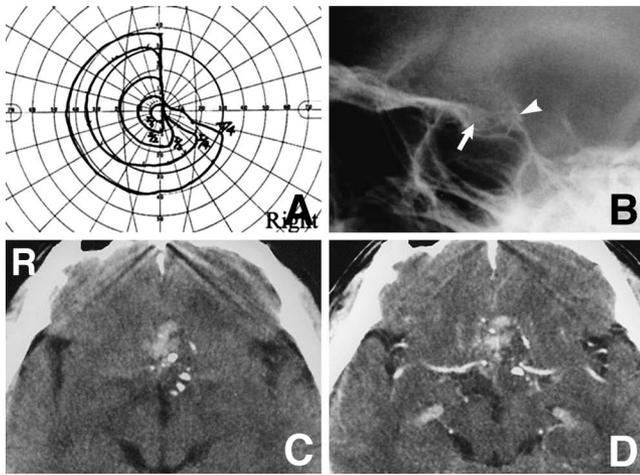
A: Ophthalmological examination revealing temporal superior quadrantanopsia of the right eye. B: Skull radiograph demonstrating suprasellar destruction (arrow) and calcification (arrowhead). C, D: Computed tomography scans showing a hemorrhagic suprasellar lesion with slight calcification (C), and enhancement with contrast medium (D).
